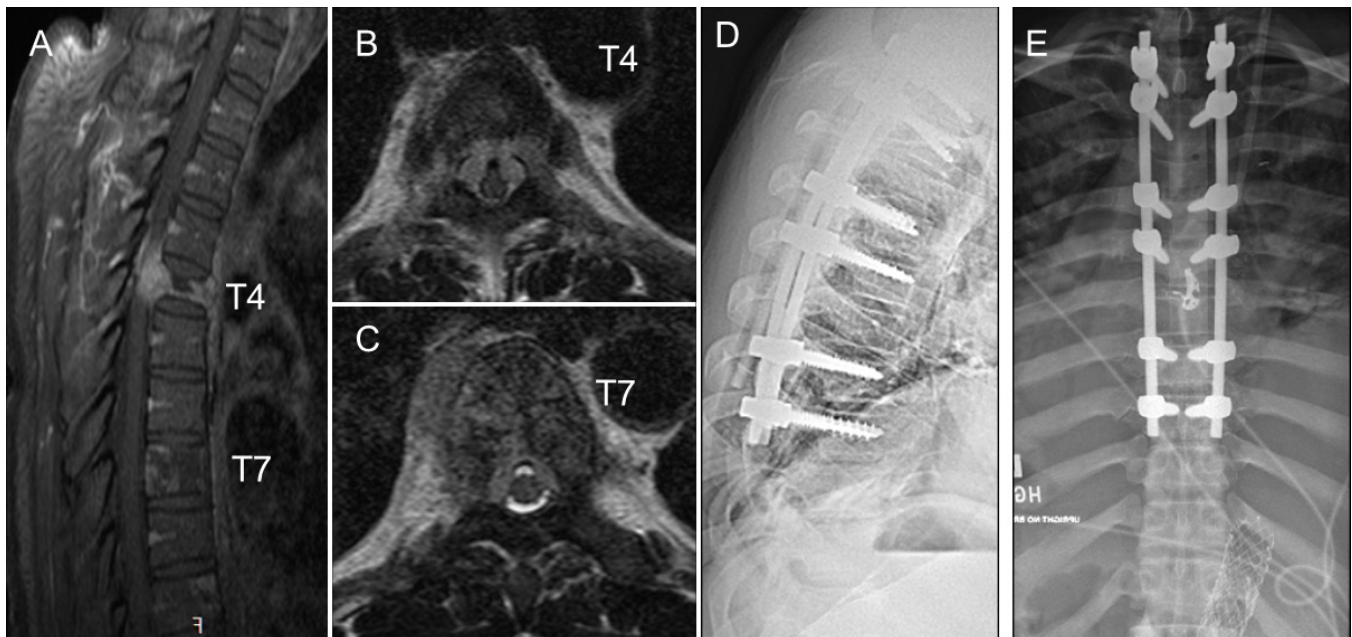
(A) 45-year-old man with renal cell carcinoma presented with worsening left upper extremity weakness and back pain. The patient had evident T4 and T7 lesions compressing the spinal cord on preoperative sagittal, contrasted T1-weighted magnetic resonance imaging (MRI) (A), axial T2-weighted MRI at T4 (B), and axial T2-weighted MRI at T7 (C). Subsequently, the patient underwent posterior spinal fusion from T2 to T9, multiple posterior column osteotomies, and laminectomy with bilateral transpedicular decompression at T4 and T7 with tumor debulking, as shown on lateral and posteroanterior x-rays (D and E).
